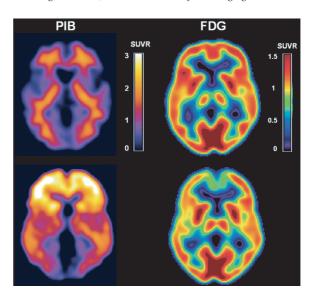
Coregistered PIB and FDG-PET scans in 2 representative cognitively normal individuals at conceivably low risk for AD (top row: negative PIB and normal FDG uptake), and at high risk for AD (bottom row: positive PIB and reduced FDG uptake) based on PET imaging findings. Cerebral-to-cerebellar PIB Standardized Uptake Value ratios (SUVR) are displayed for each modality using a color coded scale.
